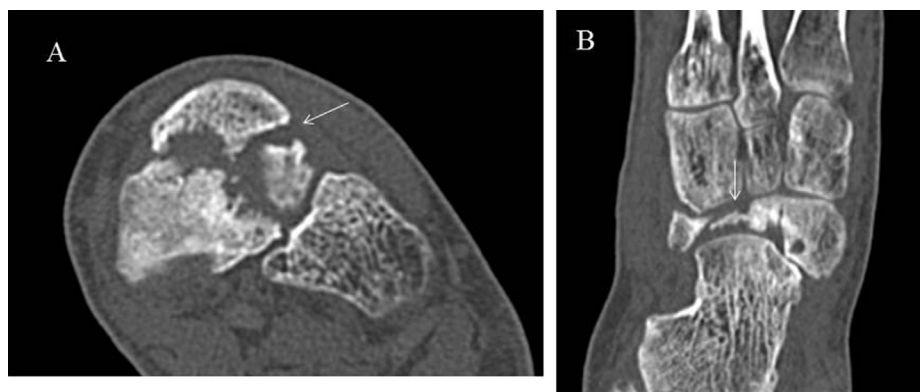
CT scan of the left foot before surgery. Fracture nonunion with an upward displacement of the dorsal fracture fragment was confirmed on the axial (A) and the coronal (B) plane of the CT scan.
